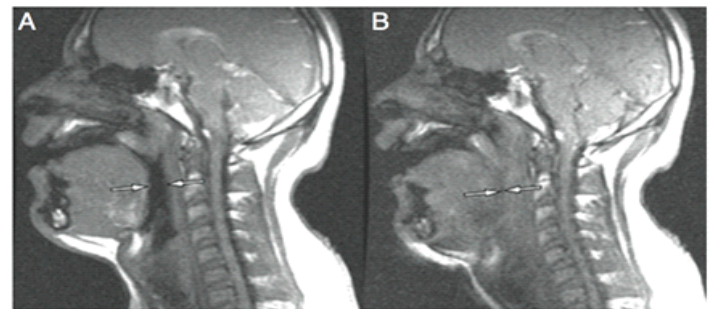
Dynamic MRI on inspiration the retroglossal airway is patent , on expiration glossoptosis and airway obstruction.
